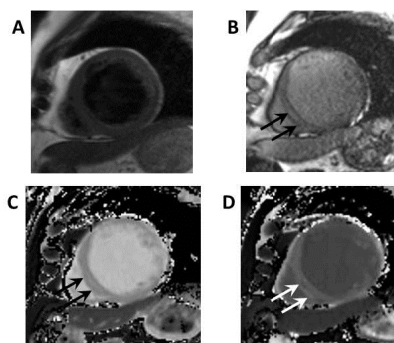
A case of DCM. (A) T1-weighted image, (B) LGE, (C) Pre-contrast T1 map, (D) Post-contrast (21 minutes) T1 map. LGE demonstrate mid-wall enhancement in inferoseptal segment (arrow). T1 of inferoseptal segment in pre-contrast and post-contrast are 1343 and 616 msec, respectively. In unenhanced myocardium except inferoseptal segment, pre-contrast mean T1 (1310 msec) is higher than normal myocardium, and post-contrast T1 (658 msec) is lower than normal myocardium.
